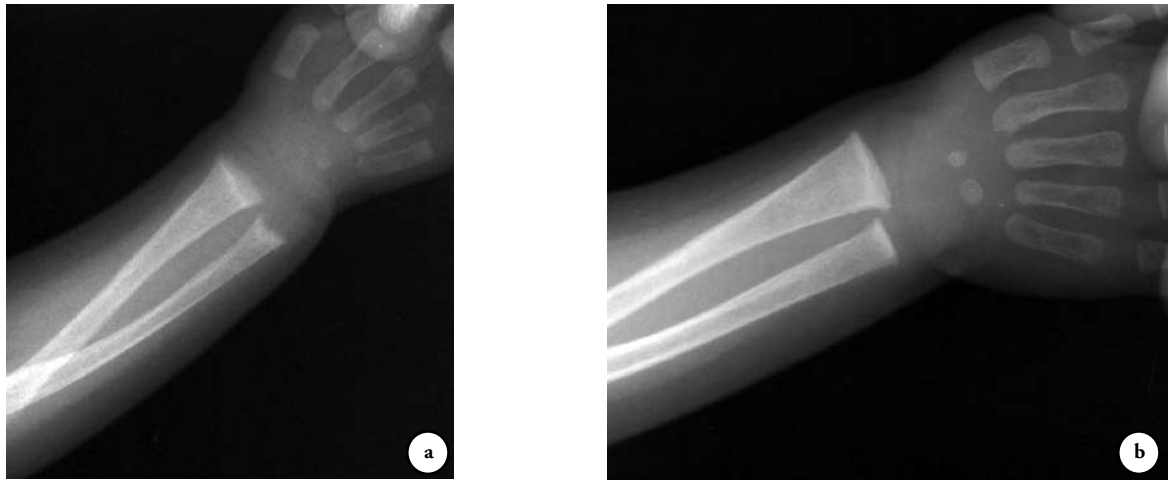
Anteroposterior wrist radiographs of an infant with rickets a) prior to, and b) 3 weeks after treatment.
